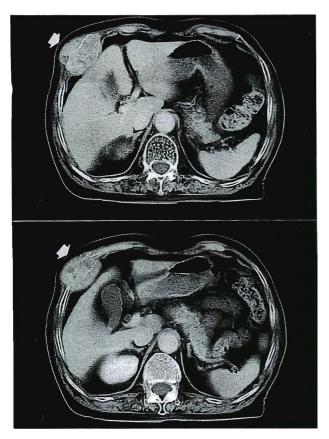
CT scans of the chest wall showing an oval tumor in the right chest wall with associated destruction of the rib (arrows).
